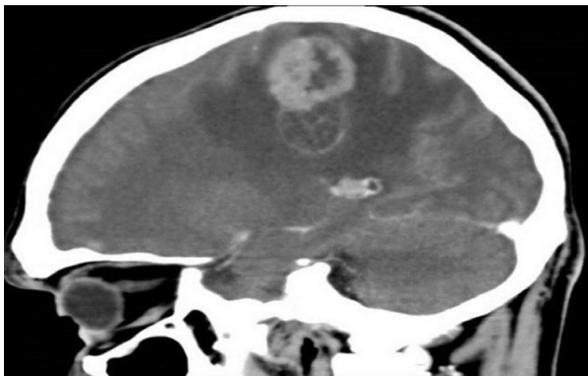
Head CT scan with contrast showing the parenchymal metastasis (Turliuc *et al.*, 2015).
